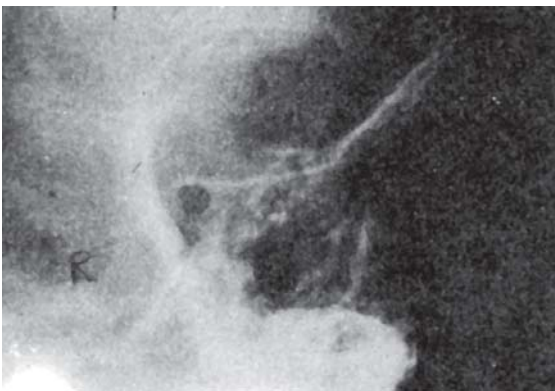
Radiograph of optic foramen
